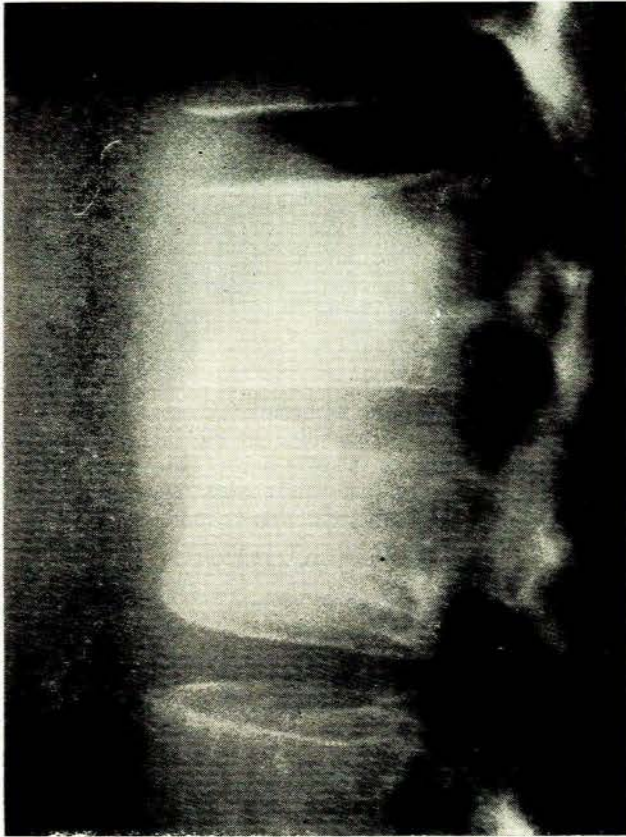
Lateral X-ray of the lumbar spine which confirms the findings in Fig. 1.
